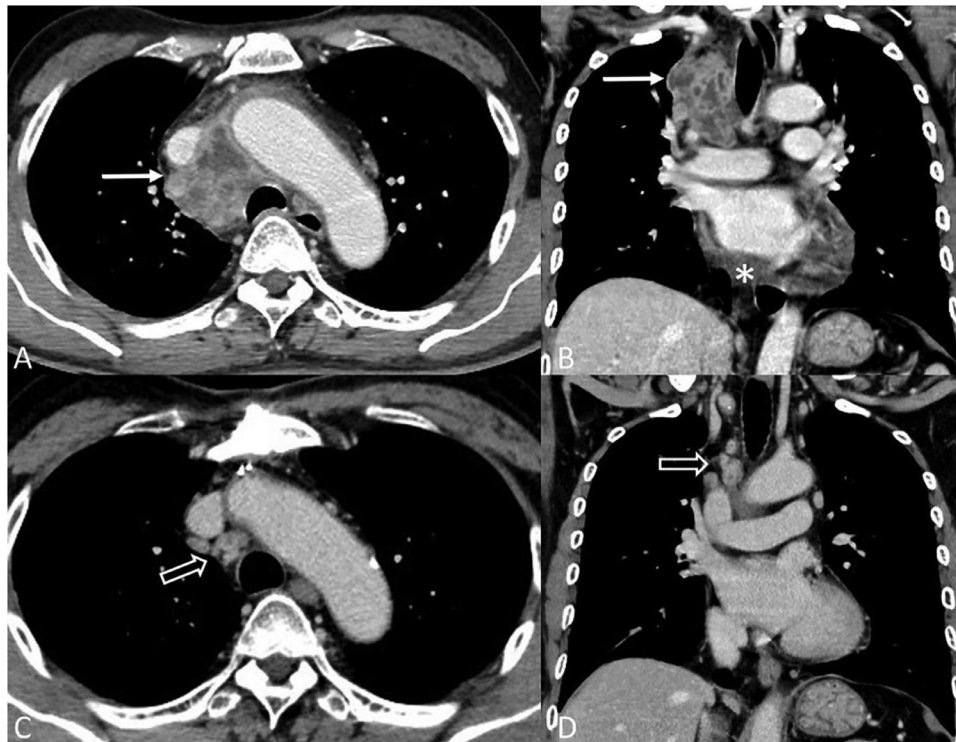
(A and B) Axial and coronal views contrast-enhanced computed tomography angiography (CTA) of the chest show multiloculated rim-enhancing lesion with internal hypoattenuation in the right paratracheal region (arrows) and a moderate amount of pericardial effusion (asterisk). After surgical drainage and intravenous antibiotics (C and D) demonstrated few small residual lymph nodes (open arrows) and resolution of pericardial effusion.
